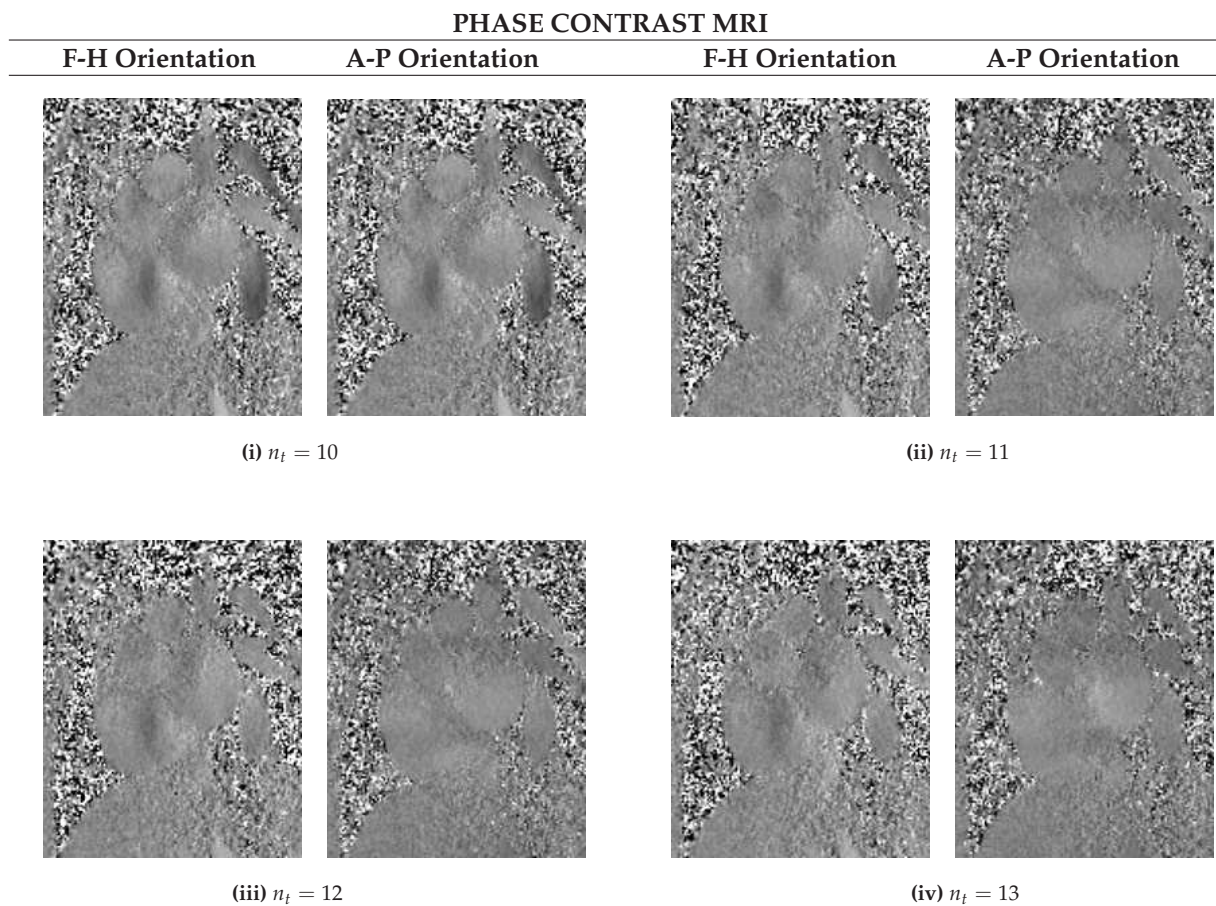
describes phase contrast in magnetic resonance imaging (MRI) based on spin phase shifts that are proportional to the blood velocity (Markl *et al.* 2003, Yu *et al.* 2003). Phase contrast MRI signals can be represented using intensity images. The intensity of each pixel corresponds to the blood velocity at the measured location. To quantify a velocity in one spatial dimension, at least two phase images must be taken for subtraction of flow-induced phase shift from background phases caused by susceptibility-induced inhomogeneities and coil sensitivity changes (Baltes *et al.* 2005). The flow sensitivity of a phase contrast signal acquisition is given the term velocity encoding and is usually abbreviated as VENC (Svensson 2003). Setting of VENC limits affects flow measurements (Lagerstrand *et al.* 2006). Blood velocity will be aliased to an artificially low value if it exceeds the maximum VENC level by the flow sensitisation gradients.
